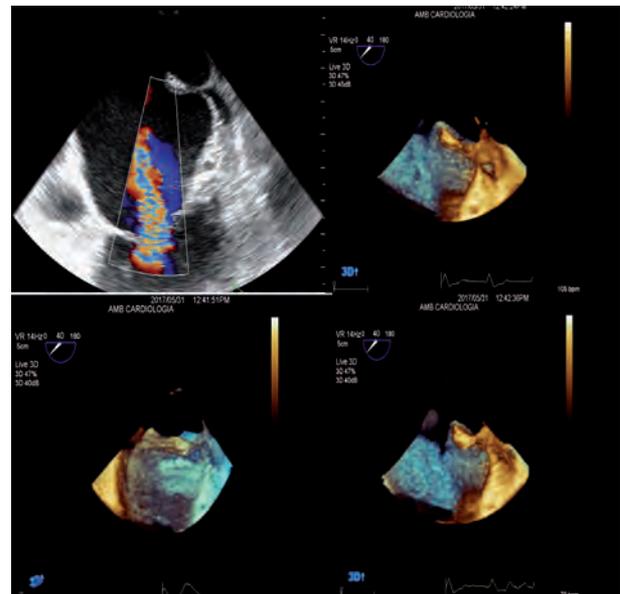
A-B-C-D. TOE demonstrates with 3D reconstruction a clear visualization of the fibromuscular band, wide opening remained between the posterosuperior and the antero-inferior portions of the atrium. No gradient developed across the membrane at continuous-wave doppler interrogation. Moderate mitral regurgitation was detected
